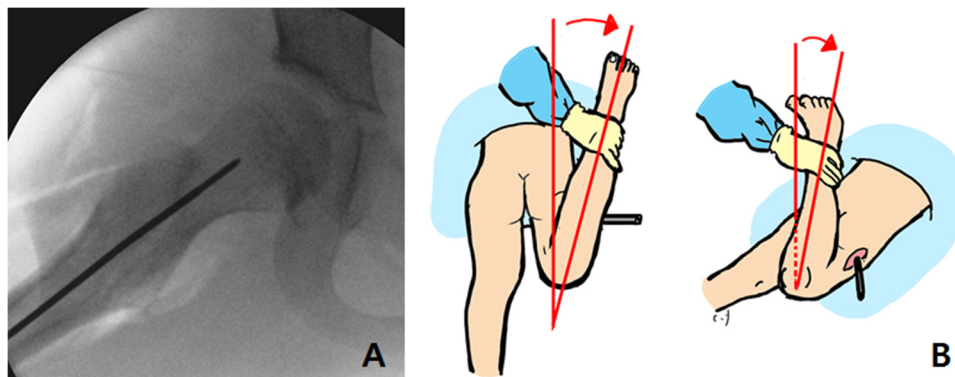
(A) A guide pin is inserted parallel to the femoral neck axis on a frog-leg lateral hip radiograph, and intertrochanteric osteotomy and derotation are performed until the modified TPAT reaches 15°. (B) The modified TPAT is defined as the angle between a vertical line and the long axis of the leg when a guide pin is located horizontal to the ground.
